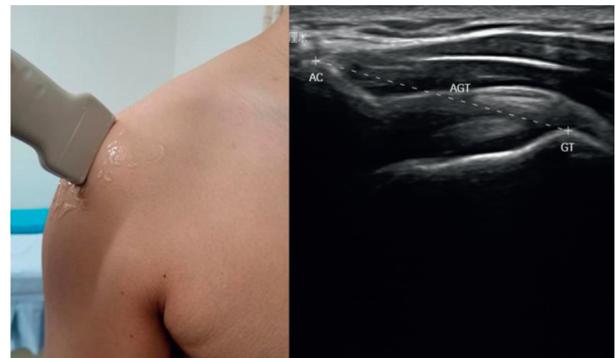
Measurement of acromion-greater tuberosity (AGT) for shoulder subluxation by using musculoskeletal ultrasound imaging technique. AC indicates acromion; GT indicates greater tuberosity.
